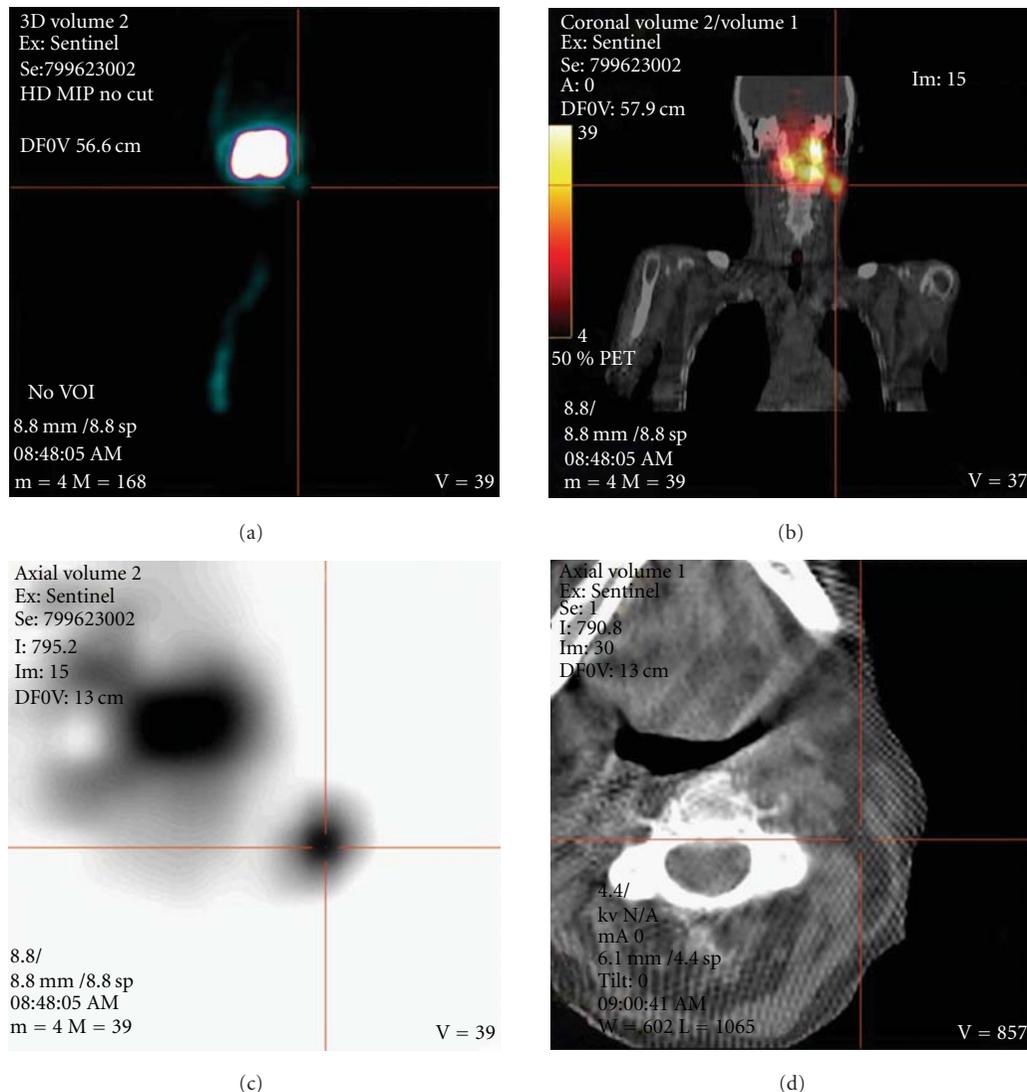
64-year-old female suffering from a left-sided tongue cancer. (a) shows the MIP (maximum intensity projection)—image of SPECT acquisition in anteroposterior view. A large uptake is seen at the injection site with a small, focal uptake of the left lower border (cross hair). (b) shows a fused coronal SPECT/CT image that localises the small focal uptake in the neck region level IIA/B. (c) shows the axial SPECT image with the corresponding cross hair in the sentinel node with a clear delineation from the injection site. (d) shows the corresponding low-dose CT scan localising the uptake by linked cross hair into the neck level IIA/B.
